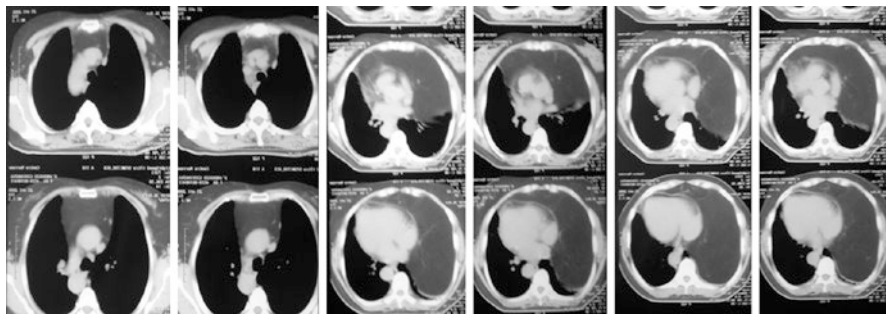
Chest CT without contrast: lipomatosis. Increase of non-capsulated adipose tissue in the anterior mediastinum extending in left hemithorax and with contralateral dislocation of medial structures
